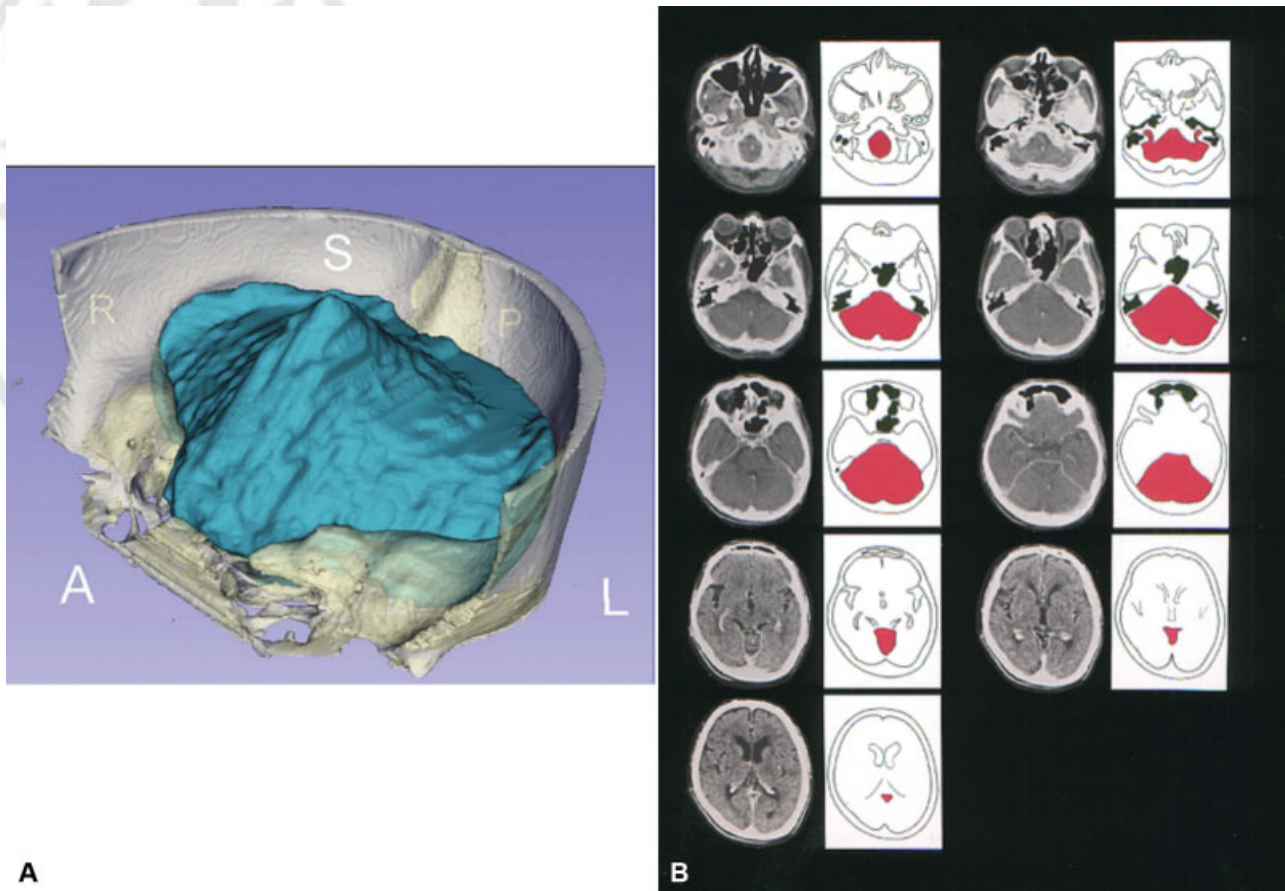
Calculation of the volume of the posterior cranial fossa (PCF). (A) Three-dimensional (3D) reconstructed image of the PCF using Osirix software. (B) Two-dimensional (2D)-computed tomography (CT) images of the PCF. The PCF was defined as the almost circular space bounded by the tentorium cerebelli, occipital bone, clivus, petrous bone, and petrous ridges. The ridges of the petrous bones form the anterolateral border of the cavity, and their connection to the posterior clinoids (posterior petroclinoid ligament) forms the anterior border. The caudal end of the PCF was defined as the foramen magnum including McRae's line. McRae's line was defined as the line between the basion and opisthion. The volume of brain in the posterior cranial fossa (VPCB) was calculated as the neural content of the PCF including the cerebellum, mesencephalon, pons, and medulla (blue areas in the left panel and red areas in the right panel). Volumetric calculations were performed using 3D radiographic analysis software (Osirix). The volume of the PCF (VPCF) was calculated using reconstructed 2D-CT images, and VPCB was calculated on magnetic resonance axial and sagittal images, excluding the fourth ventricle and herniated cerebellar tonsils and medulla. VPCF was divided into the volume above Twining's line (the line between the tubercle sellar and internal occipital protuberance) and below Twining's line.
